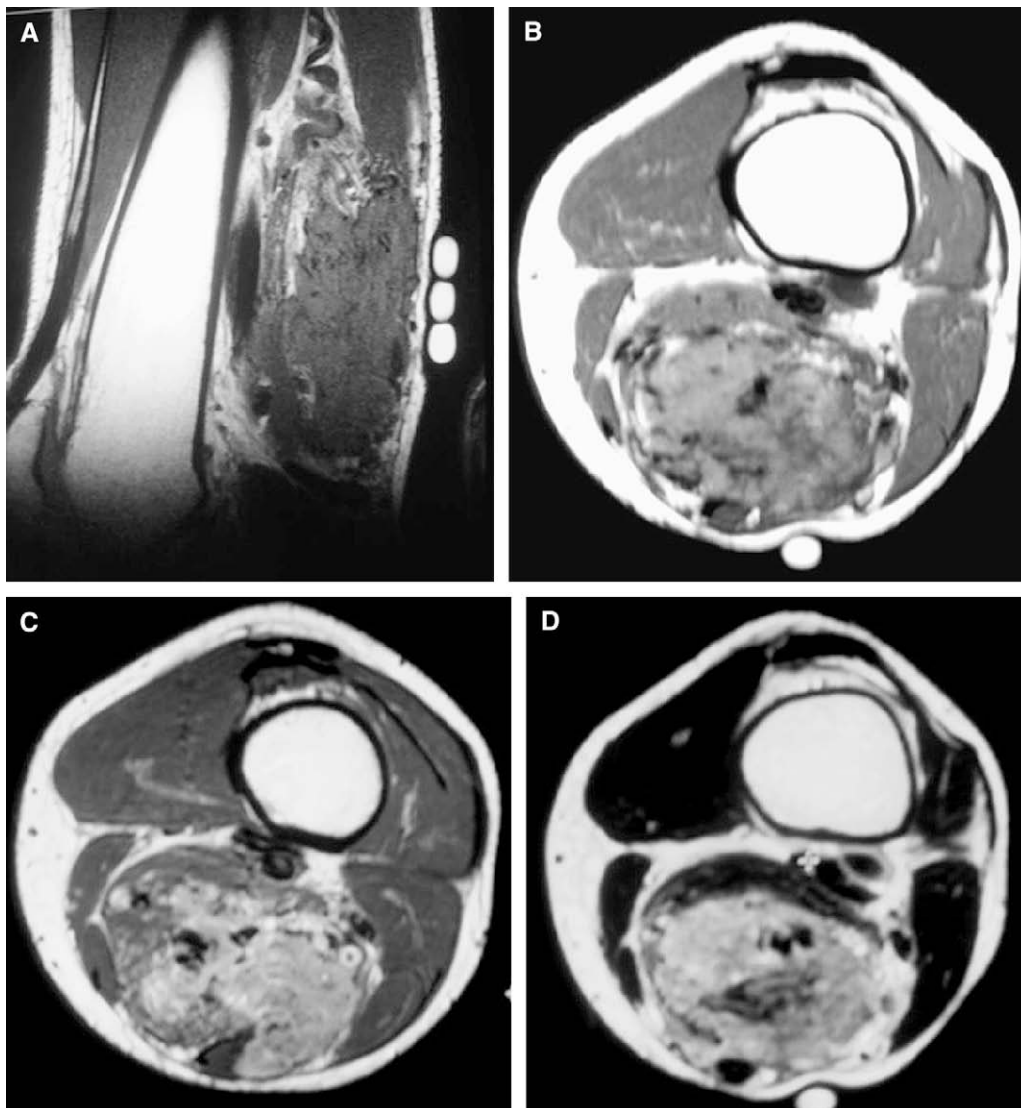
(A) Sagittal T1-weighted image through the left distal femur. (B) Transverse T1-weighted image through the left distal femur. (C) Transverse contrast-enhanced T1-weighted image through the left distal femur. (D) Transverse T2-weighted image through the left distal femur.
